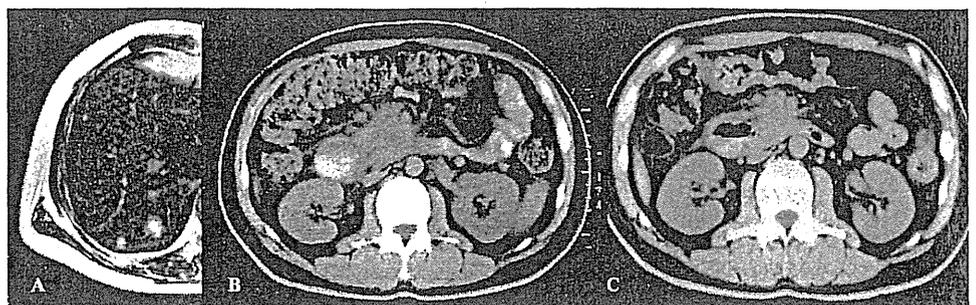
A: MRI of the liver shows multiple metastases in patient 2. B: Pancreatic tumor located in the head of the pancreas in patient 2 before NST. C: The tumor decreased 40% in size on day 30 after NST.
